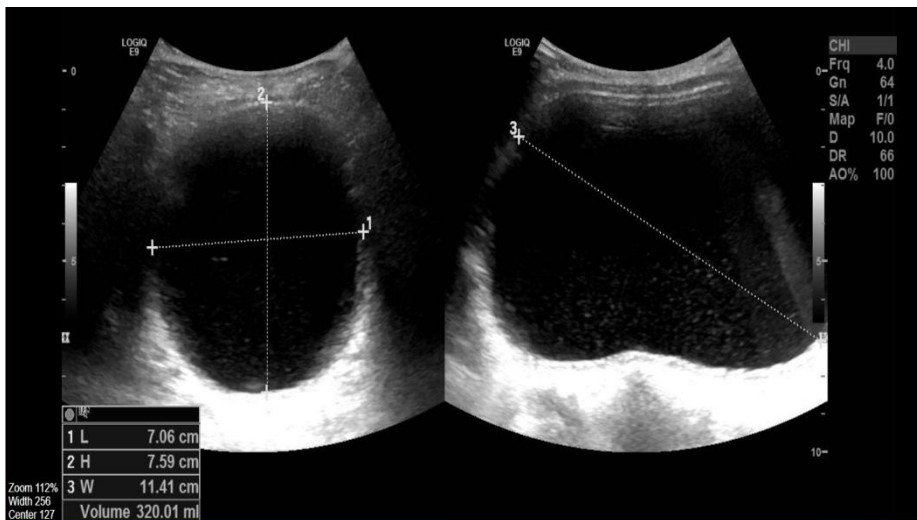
Urinary bladder ultrasound demonstrating cystitis and retention. Ultrasound performed in September 2021 for urinary retention/meatal stenosis shows a distended urinary bladder (volume ~320 mL; dimensions L 7.06 cm × H 7.59 cm × W 11.41 cm) with turbid intravesical fluid, consistent with cystitis in the context of recurrent obstructive uropathy (meatal/urethral stenosis) associated with congenital junctional epidermolysis bullosa.
